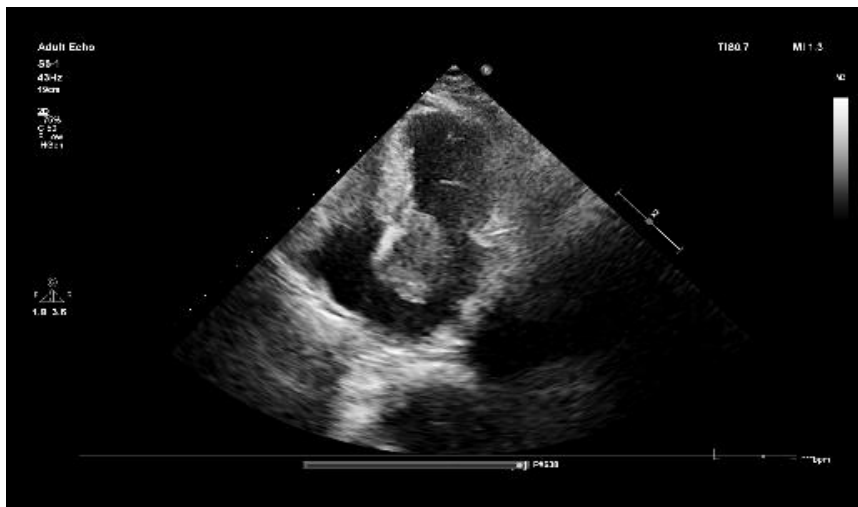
Apical four-chamber echocardiographic view demonstrating large left atrial myxoma attached to interatrial septum.
